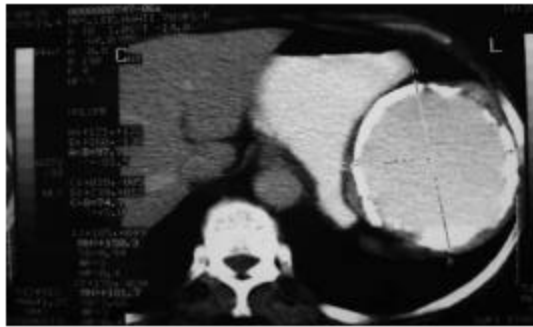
CT scan of the abdomen showing a well-defined rounded mass with dense calcification in the superior pole of the spleen
